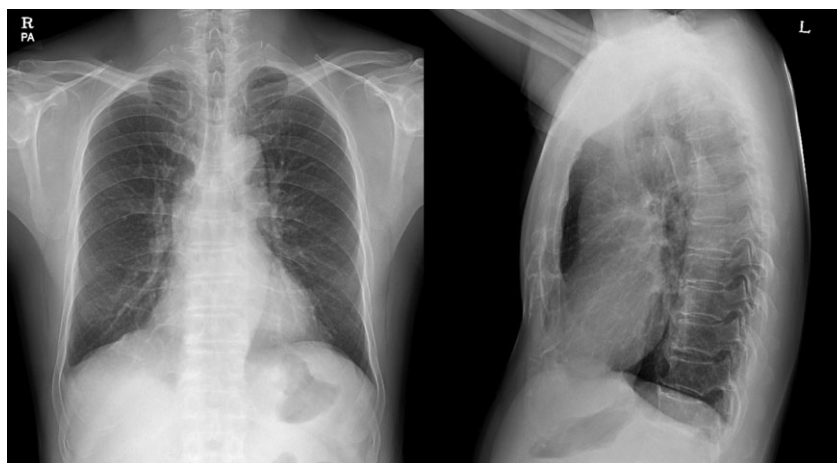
The posteroanterior and lateral chest X-rays show mild fattening of the diaphragms.
